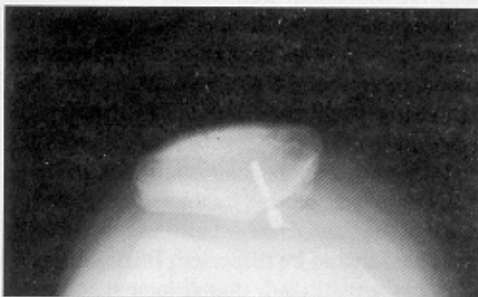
Radiograph of compression screw holding an osteochondral fragment during healing. This lesion healed and the screw was removed six months after the injury. Both surgeries performed with keyhole techniques
